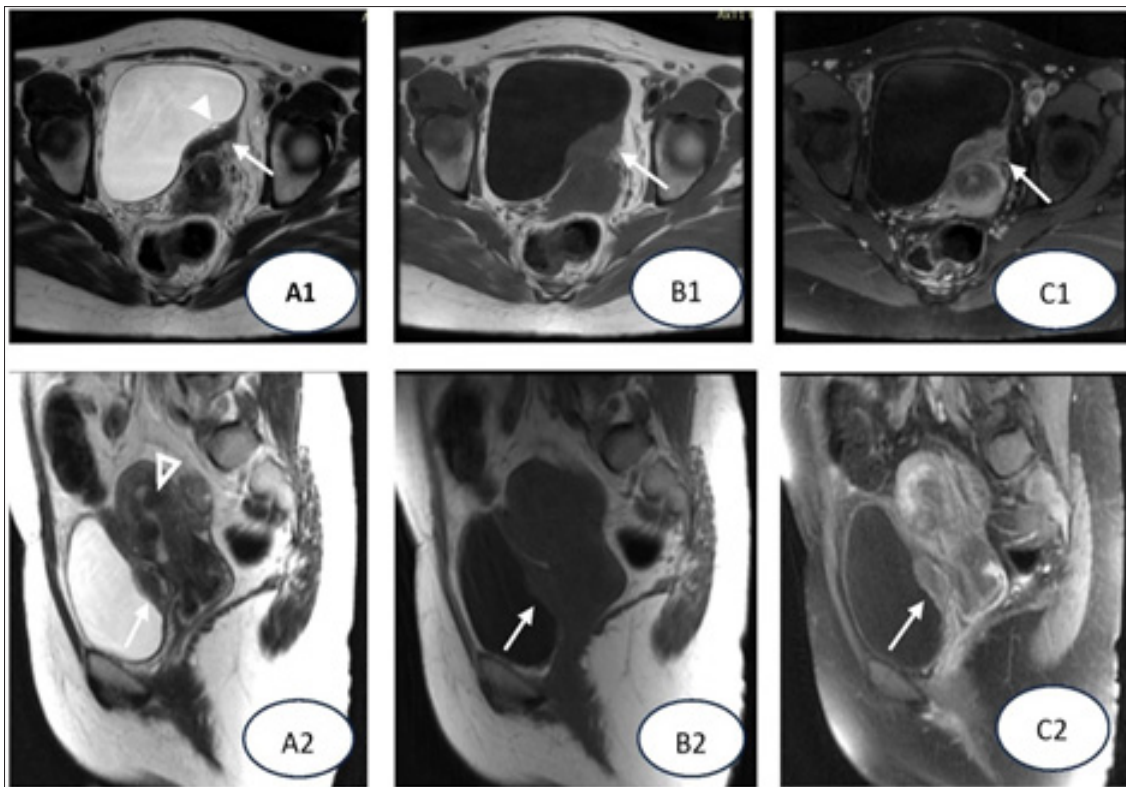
MRI Pelvis: Axial and Sagittal T2W (A1, A2), Axial and Sagittal T1W (B1, B2), and Axial and Sagittal T1W post contrast (C1, C2) images of pelvic MRI showed the presence of a variable signal intensity mildly enhancing lesion involving the left postero-lateral urinary bladder wall (white arrow), inseparable from the cesarean section scar. The lesion was having with few small T2W hyperintense internal cystic areas (white arrow head). Findings were suggestive of urinary bladder wall endometriosis. Submucosal small uterine leiomyomas are also evident (white open arrow head).
